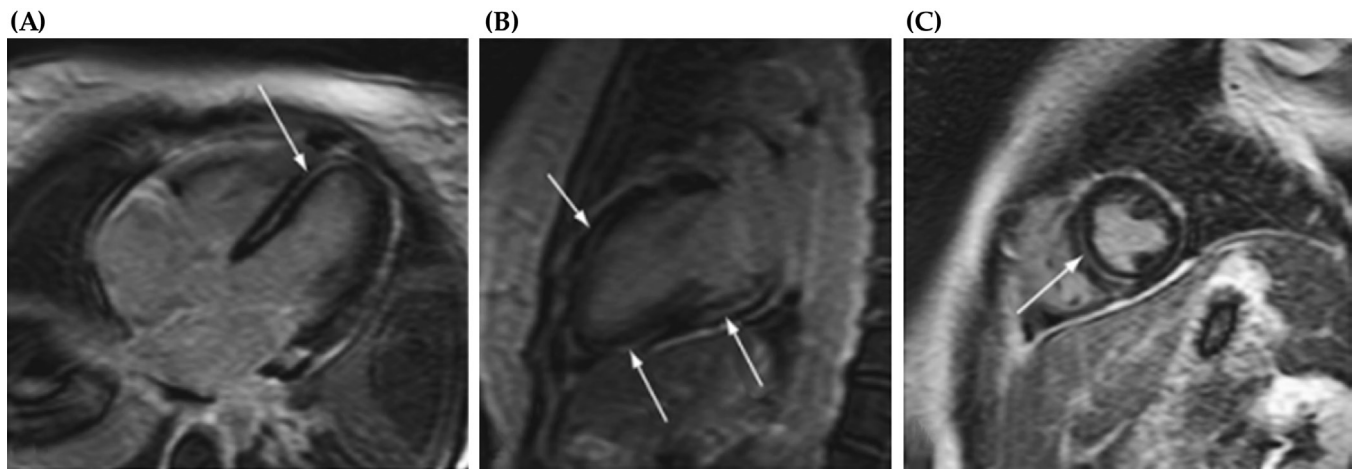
Lupus myocarditis. MRI shows enhancement of the myocardium, which spares the endocardium. (A–C): Contrast-enhanced inversion recovery technique with late imaging after contrast administration in horizontal long-axis plane (A), vertical long-axis plane (B), and short-axis plane (C). Strong enhancement is found in the midwall of the ventricular septum (A and C), in the apex (A), and in the midanterior and posterior wall (B). Reprinted from Elsevier Lupus Image Bank [148].
